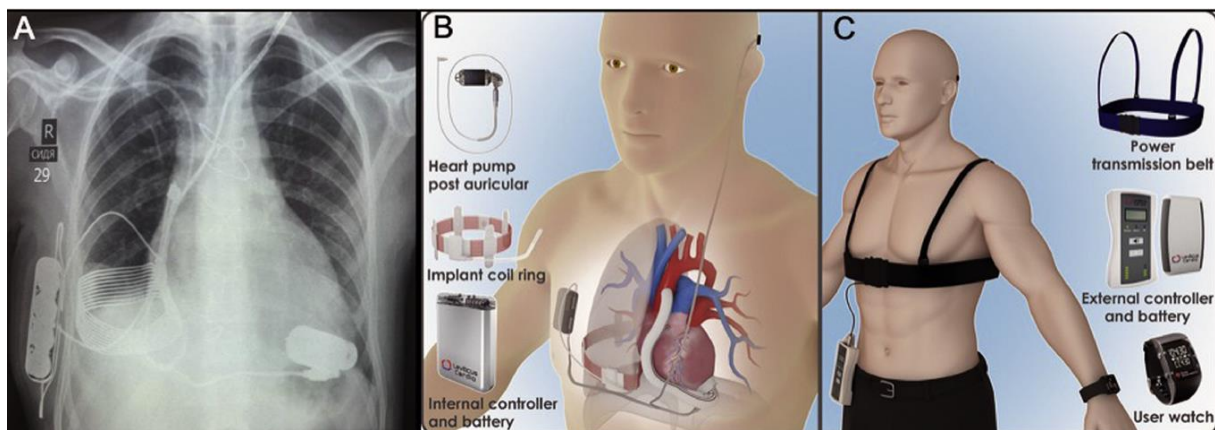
(A) Chest X-ray depicting implantable components topography. (B) Implantable components. (C) External components. Image from (Pya *et al.*, 2019)
